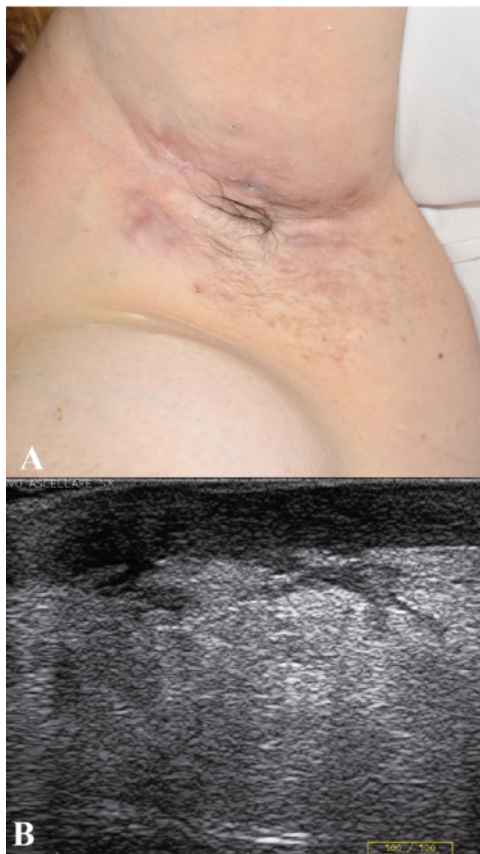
A) Clinical picture of the right armpit at baseline; B) ultrasound picture of the draining tunnel in the right armpit at baseline (fibrosis score 1, edema score 2).
